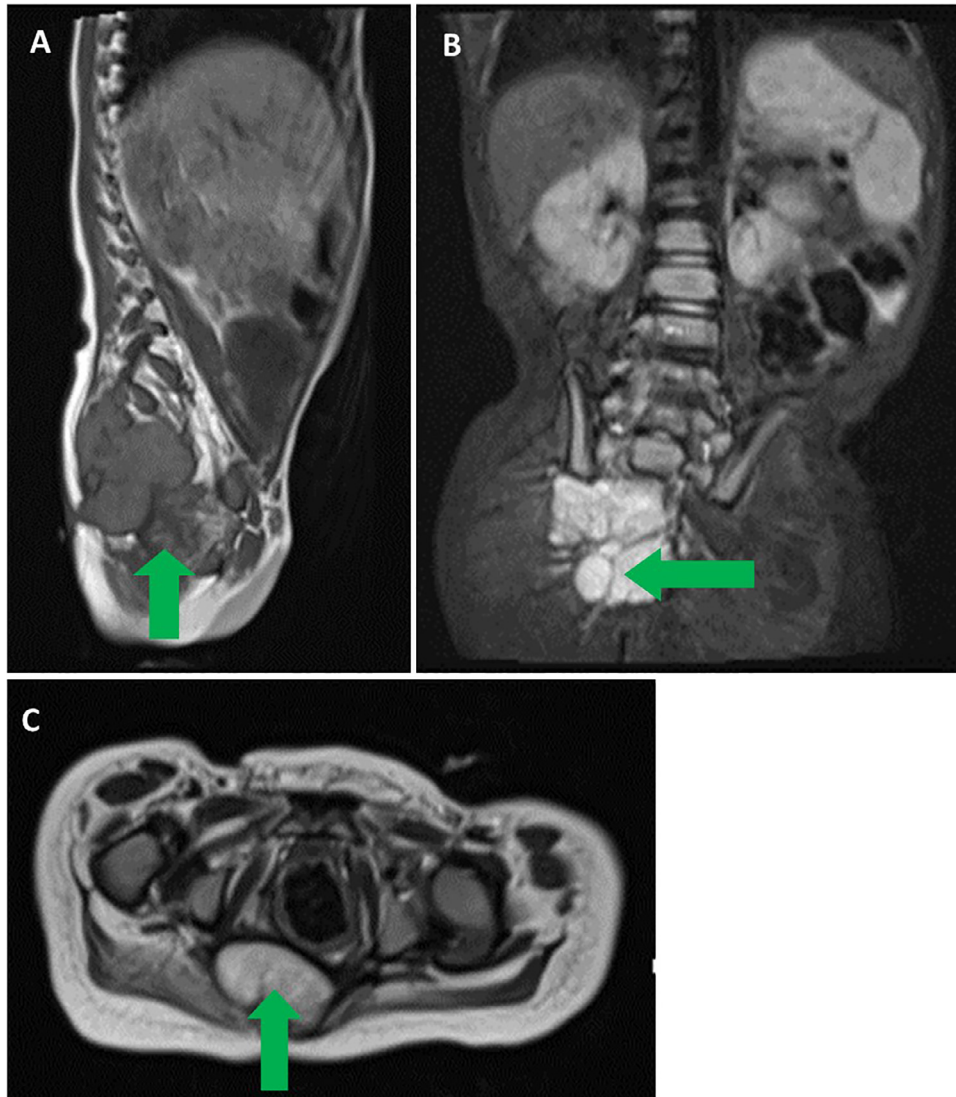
Pelvic MRI showing sacrococcygeal mass measuring 3.5 x 4.5 x 6.3 cm, with infiltration of the sacral canal up to the level of S2, suggestive of disease progression (green).
